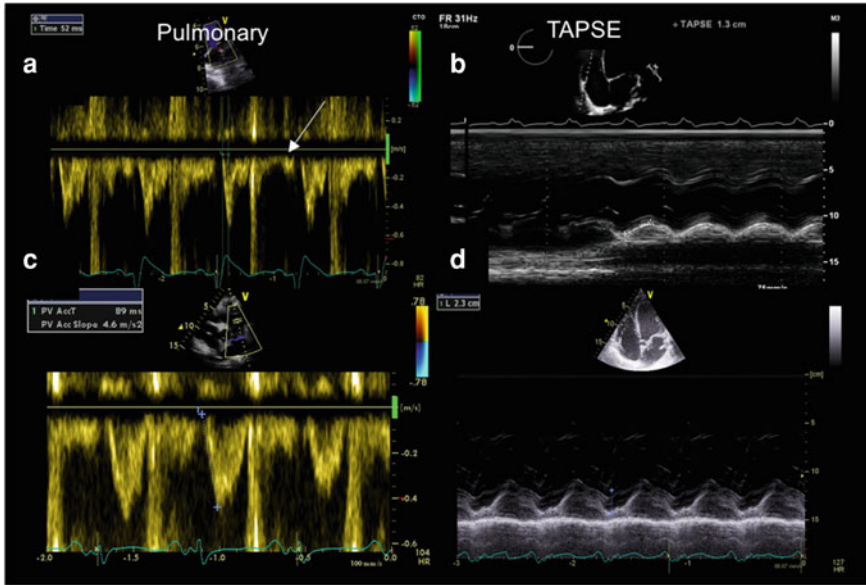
The effects of altering coronary perfusion and RV afterload on echocardiographic parameters of RV function in a patient with cardiogenic shock. Upper panel before treatment. a Pulmonary arterial Doppler showing a short acceleration time (52 ms) and very short ejection time. A small pre-systolic A wave is also seen (arrowed) except during delivery of a positive pressure breath. b Corresponding TAPSE of 1.3 cm. In the context of significant inotropic support this is significantly impaired. Lower panel after treatment with iNO, levosimendan, nebulised prostacyclin and low-dose vasopressin plus insertion of an IABP, reduction in noradrenaline dosage and stopping adrenaline infusion. c The pulmonary artery Doppler shows the acceleration time to be normal, and the right heart VTI was significantly increased. d TAPSE has increased to 2.3 cm. The corresponding measured cardiac index in this patient increased from 1.3 to 2.6 L/min/m²
